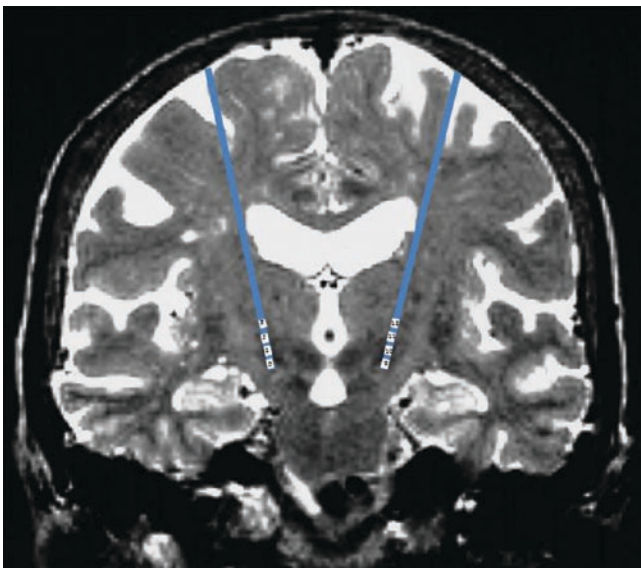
Coronal brain MRI image with superimposed Medtronic 3389 DBS brain leads placed in the subthalamic nucleus. Brain leads have four contacts/electrodes (designated as 0, 1, 2, 3 on the left and 9, 10, 11, 12 on the right)
